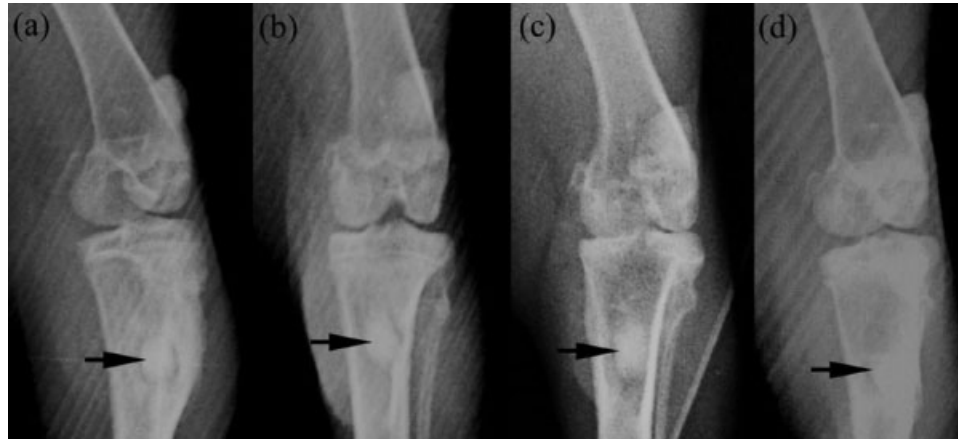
Radiographs of the cement after implantation: (a) 3 days; (b) 4 weeks; (c) 8 weeks, and (d) 12 weeks.
